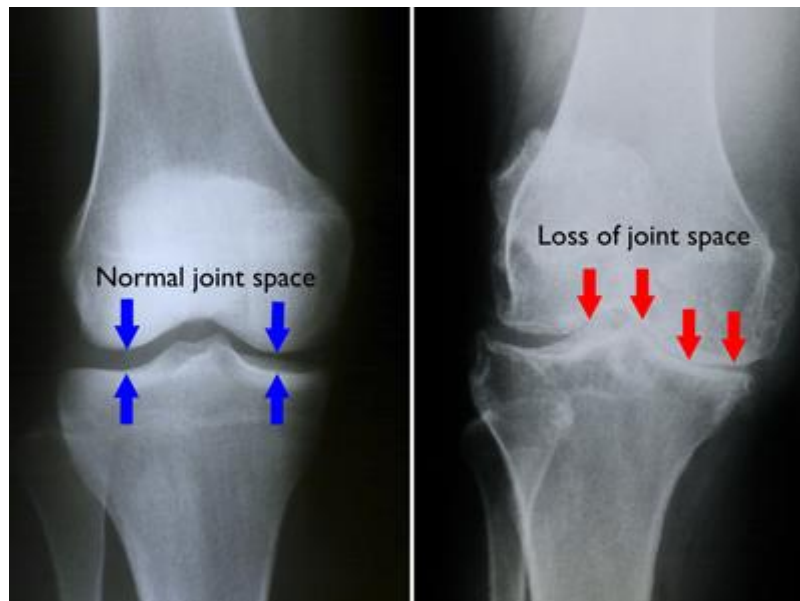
X-ray images showing narrowing of the joint space in (A) a healthy knee joint, and (B) a knee joint affected by osteoarthritis (Arthritis of the Knee-OrthoInfo - AAOS, 2012).
